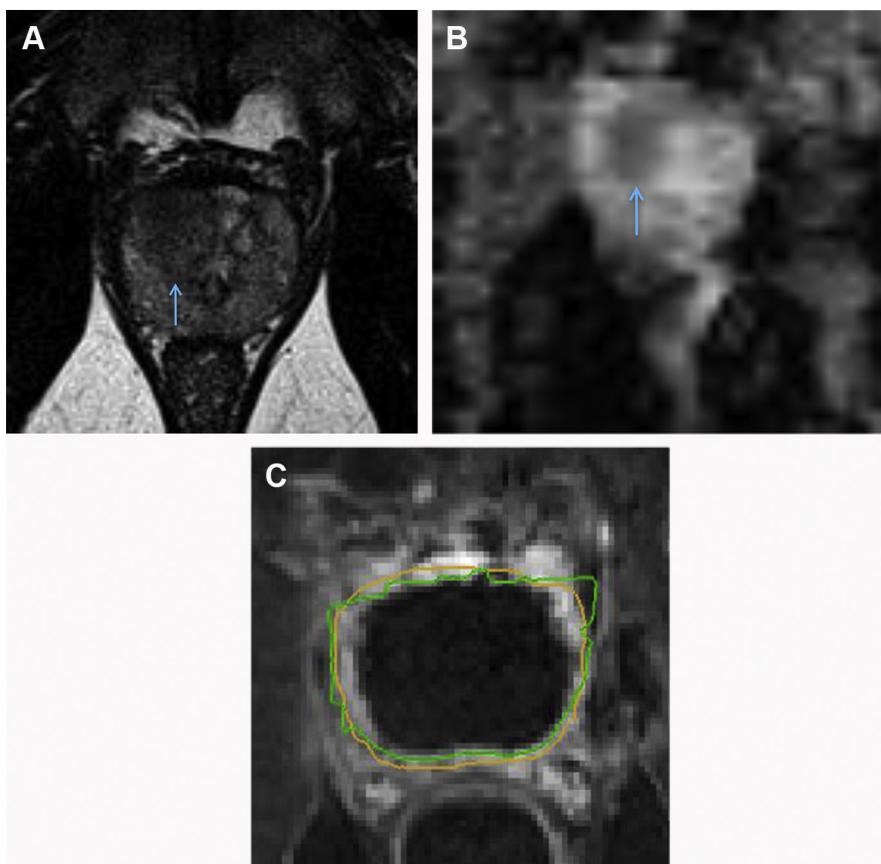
HIFU treatment. A 56-year-old man with a history of Gleason 3 + 4 prostate cancer and a PSA value of 8.1 ng/mL underwent HIFU therapy for a right-sided transition zone cancer evident on MR imaging (arrows). (A) A rounded T2 hypointense lesion is identified in the right transition zone of the gland. (B) The lesion demonstrates restricted diffusion with corresponding decreased ADC signal visualized. (C) Post-treatment dynamic MR imaging after the administration of intravenous contrast shows expected avascularity of the gland. The green/yellow lines are indicative of the region of interest, the prostate gland.
